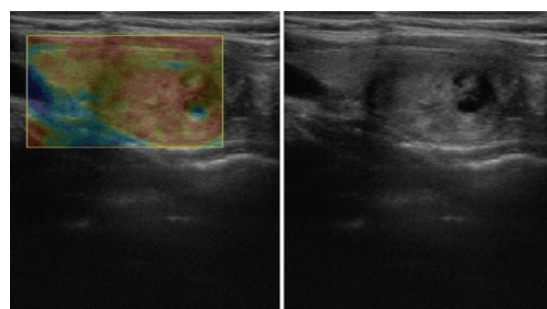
Ultrasound elastography image of the thyroid. Note: Red areas represent tissue of hard consistency, blue areas represent tissue of soft consistency. On the right : The same nodule imaged in regular 2D/B-Mode.
